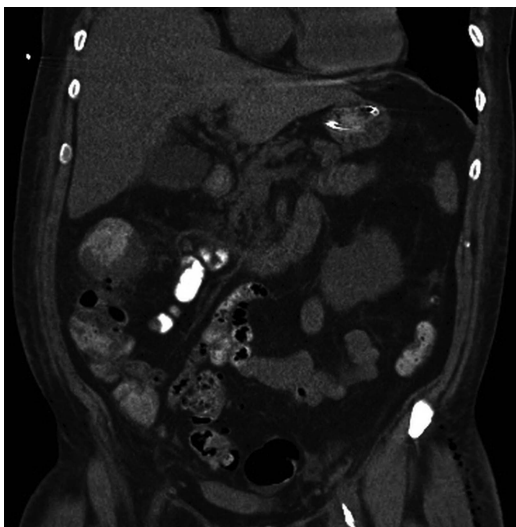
Coronal section abdominal CT scan showing bulky circumferential tumour in distal ascending colon/hepatic flexure. After *Clostridium septicum* grew from tissue cultures, it was an indication to exclude colonic neoplasms.
